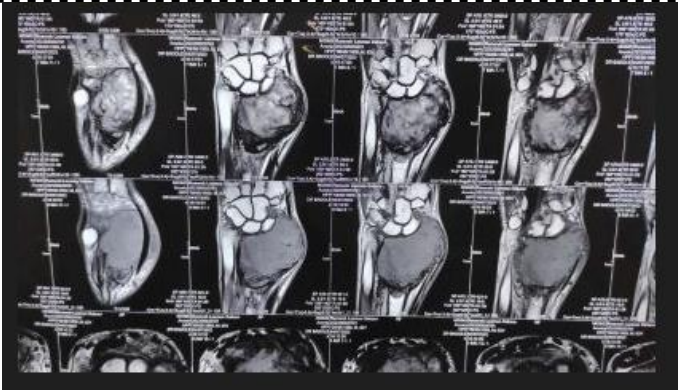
MRI of Right wrist showing peripheral non uniform non enhancing intermediate signal intensity rim causing complete destruction of distal end radius approximately of size 6.4 x 5.8 x 4.8 cm.
